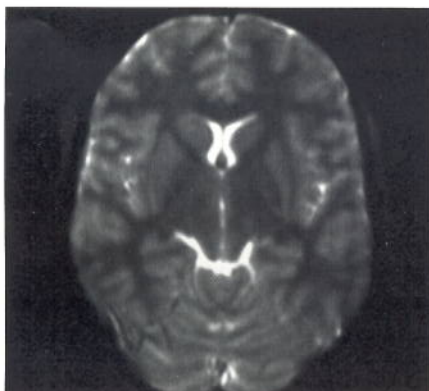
Echo Planar for ultrafast heavily T2-weighted imaging of uncooperative patients.
